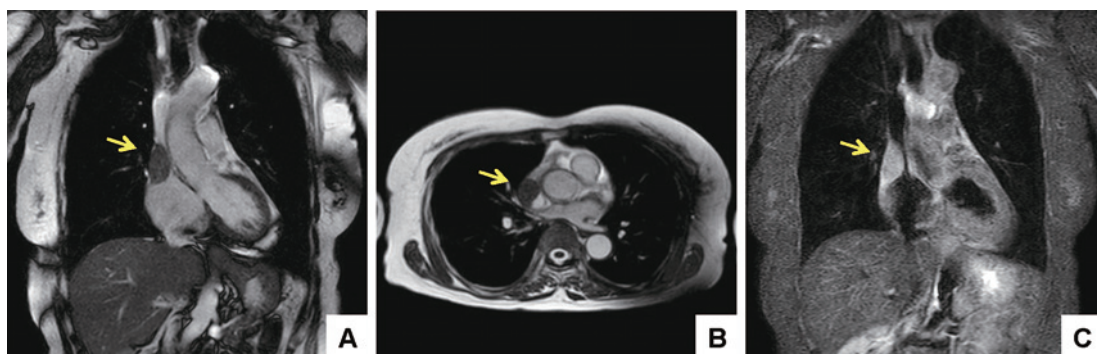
A, B: T1-weighted magnetic resonance imaging (MRI) showing a well-demarcated intracavitary right atrial mass, extending into the superior vena cava. C: T2-weighted MRI showing a hyperintense mass.
